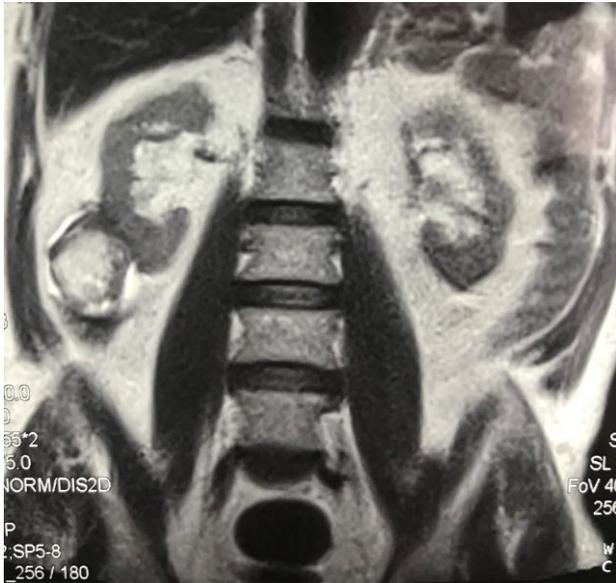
Abdominal MRI; round formation with a double fluid component and another of a difficult to determine nature.
